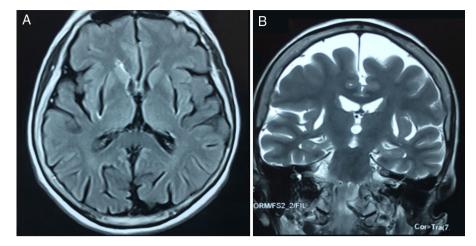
Axial FLAIR (A) and coronal T2-weighted (B) MRI sequences showing bilateral absence of the putamina.
